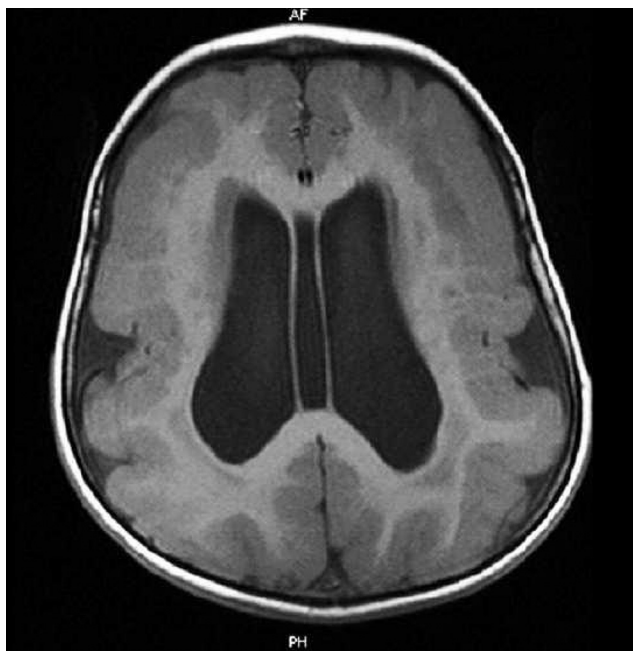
T₁-weighted brain magnetic resonance imaging of a 1-year-old child (patient number 18) with glutaric aciduria type 1 showing thick cerebral cortex with poorly developed sulcal and gyral formation. Wide Sylvian fissure is partially visualized.
